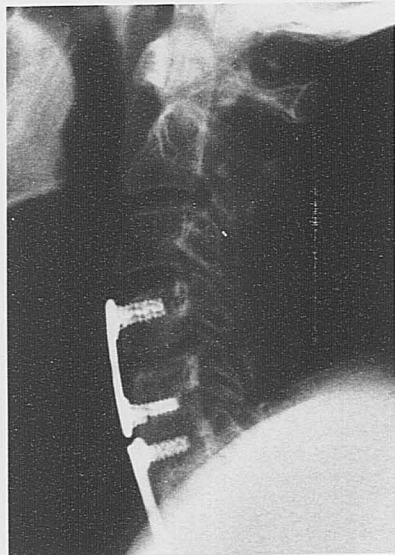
Lateral radiograph from case 2 demonstrates unilateral fracture of fenestrated screw and nonfailure of contralateral solid screw. Evidence of nonunion is present at C4-C5 8 months after surgery.
